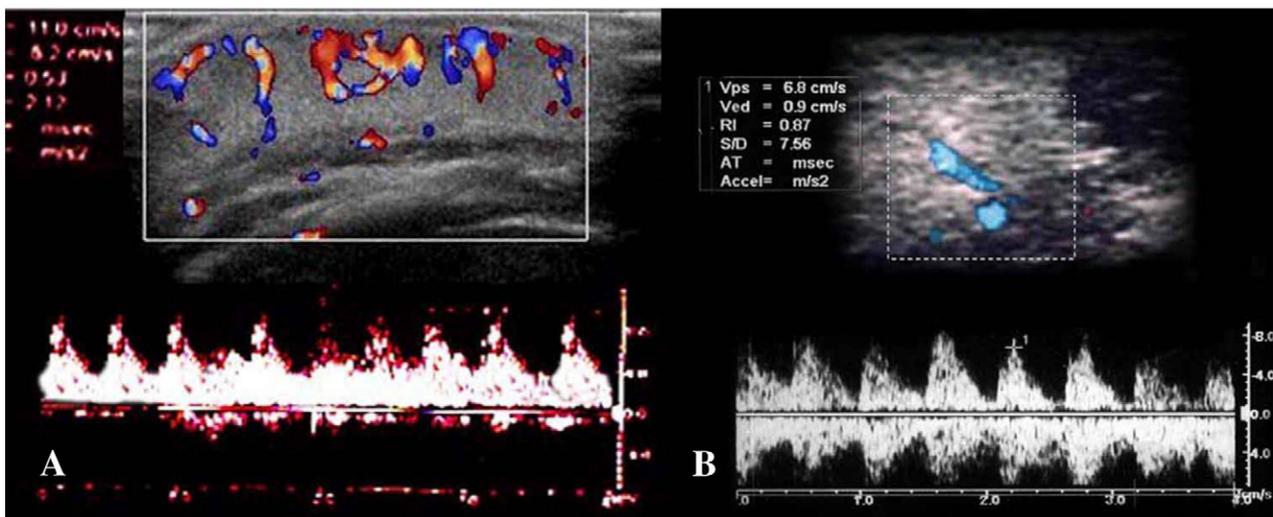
Sonographic assessment of the thickness and RI of an IH. Before treatment (A) and after treatment and 6-month period of follow-up (B).
